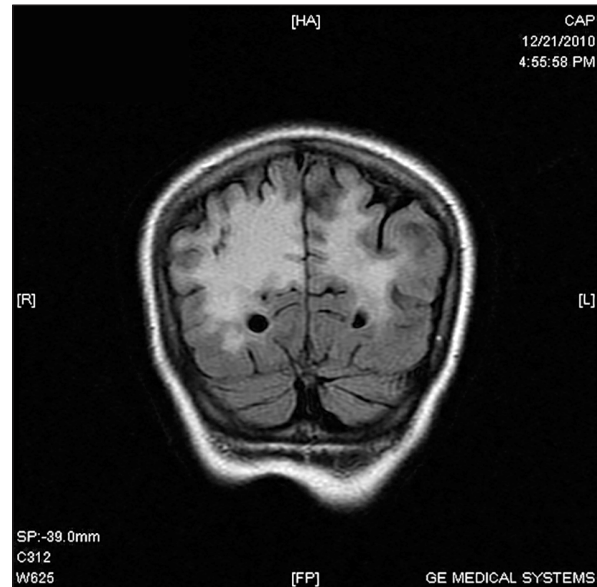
Cerebral MRI hyperintense areas on T2-weighted images, coronal view; the lesions are located parieto-occipital, bilateral
